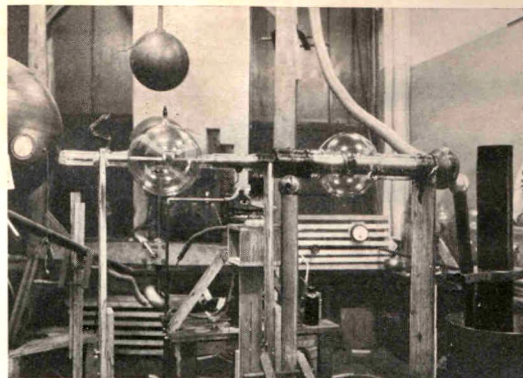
A 500,000 volt x-ray tube built in two sections.
